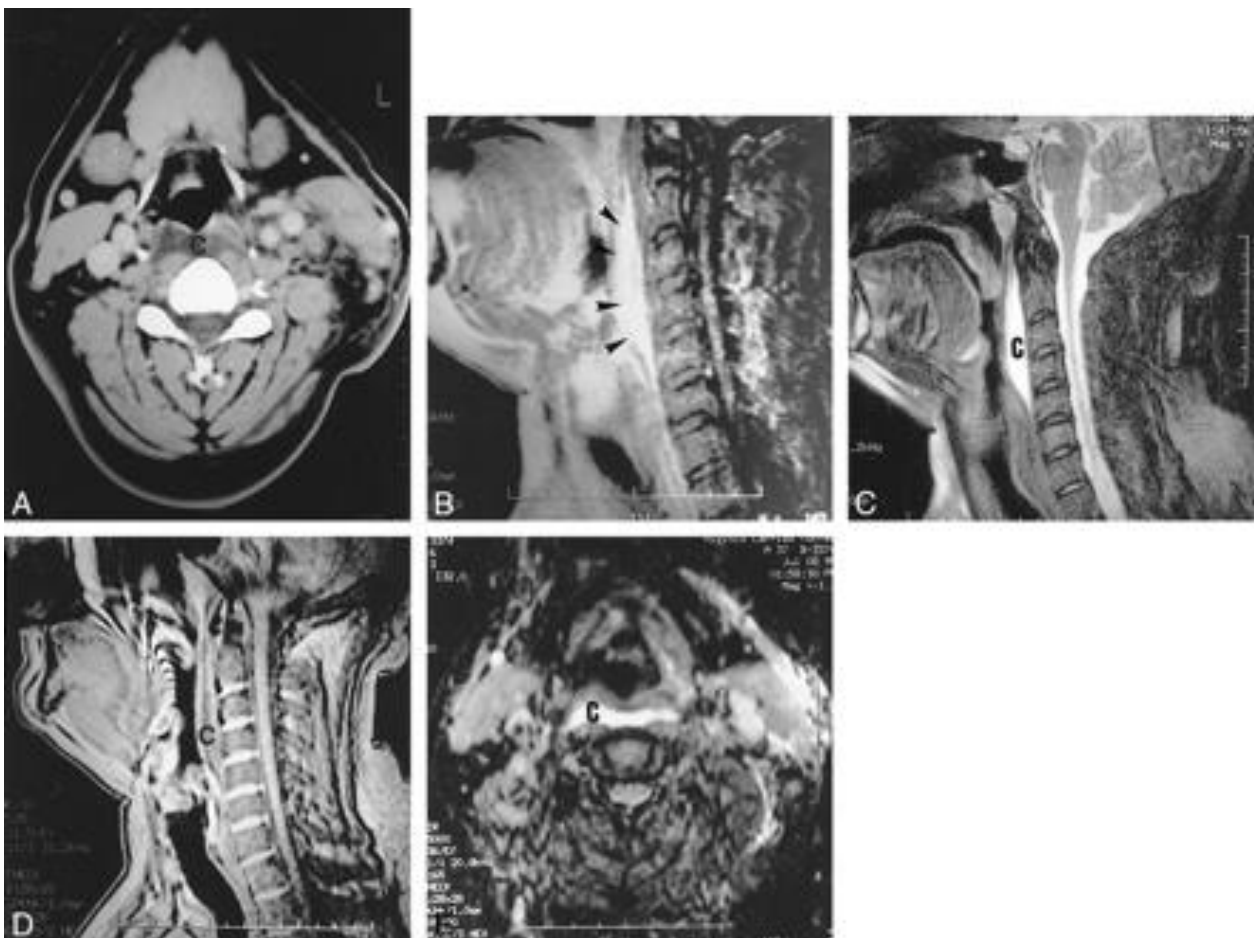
Retropharyngeal hematoma. in Enhanced CT scan ⁽²¹⁾
